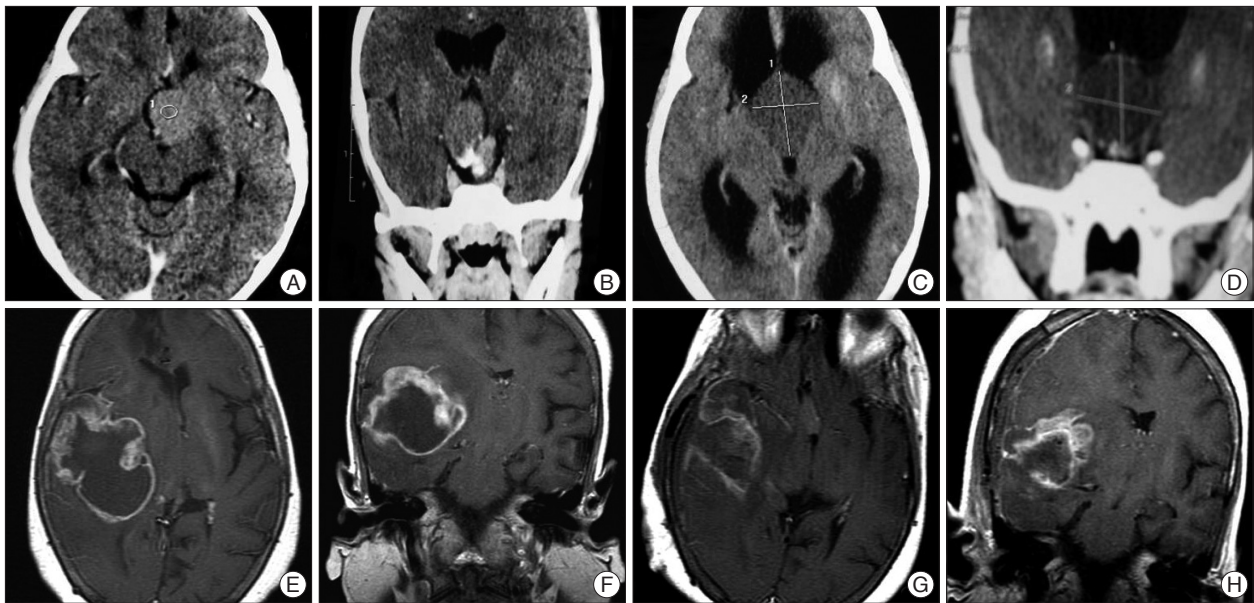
A and B : Images demonstrating the craniopharyngioma at recurrence. These were the earliest CT images available. C and D : Images demonstrate the lesion with hydrocephalus when the patient had presented to our institute for the first time. E and F : Images are T1 weighted MRI images demonstrating the right temporal GBM. There is peripheral contrast enhancement with central necrosis. Mass effect and midline shift is demonstrated. G and H : Images are post operative MRI images delineating the tumor cavity with near complete excision.
